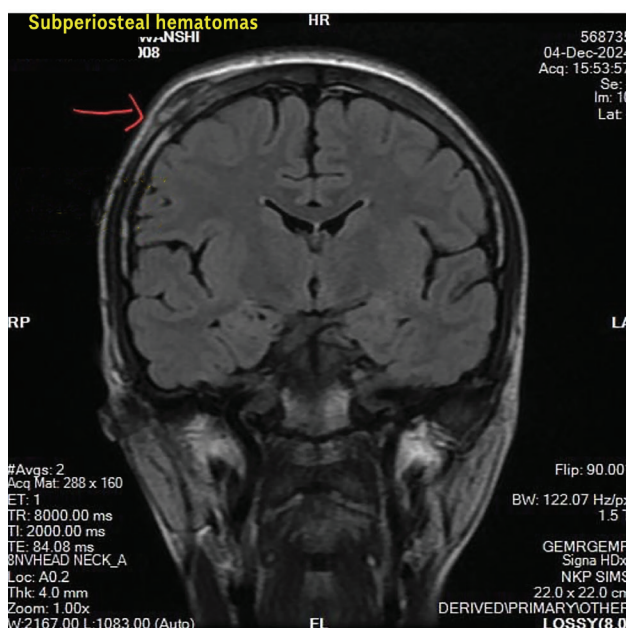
MRI brain with contrast showing right sided subperiosteal haematoma
